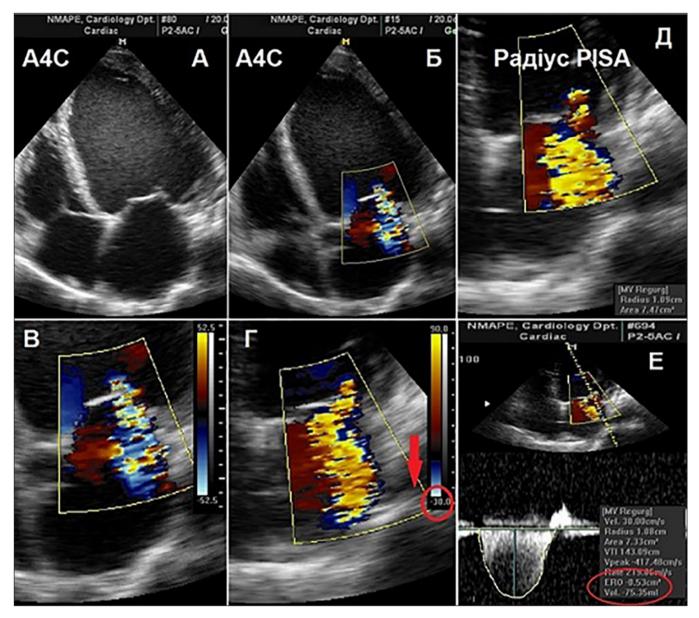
Quantitative evaluation of the difficulty of MR using the PISA method: A. A4C position; B. Doppler color flow mapping (CFM); B. "Zoom" mode of the area of interest; D. Lowering the zero line of the colored speed scale to obtain the PISA hemisphere; D. Determination of the radius of PISA using the first eleasing; E. Continuous-wave MR spectrum: manual contouring to determine VTI, allowing calculation of EROA and Rvol. (VTI – Velocity Time Integral) [13].
